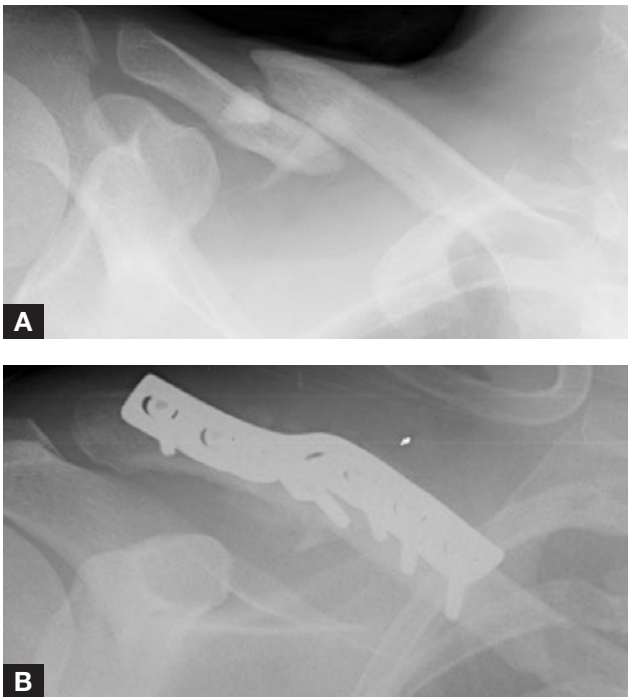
(A) Radiograph of painful midshaft clavicle nonunion 6.5 months after injury. (B) Postoperative radiograph of midshaft clavicle nonunion treated with open reduction and plate fixation augmented with iliac crest aspiration. (C) Healed nonunion with bridging callus 1 year after surgery.
